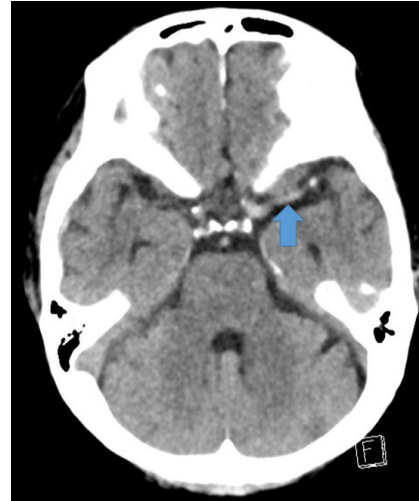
computed tomography of the brain with left dense MCA sign (Blue arrow)
